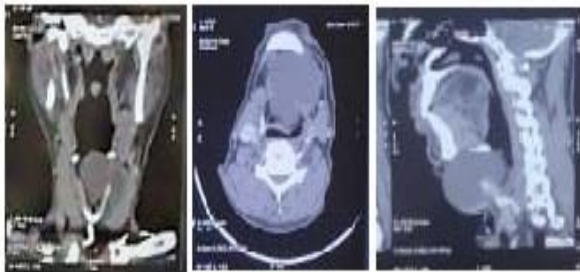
CT images showing cyst bulging in to the larynx in coronal, axial and sagittal plane.
